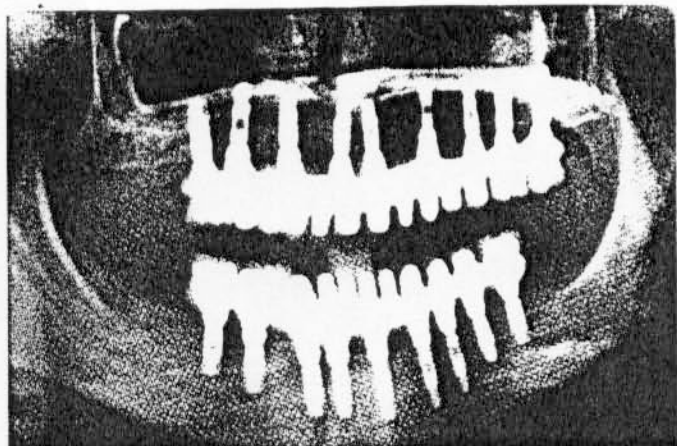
The control x-ray is optimal
